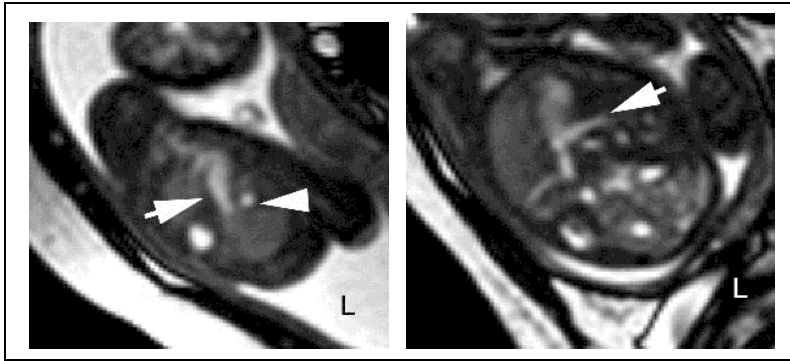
Left superior vena cava (SVC) diagnosed by axial T2-SSFP MRI at 26 weeks' gestation. (A) Three-vessel axial image documents absent right and persistent left SVC (arrowhead) as well as right sided aortic arch (arrow). (B) Axial MR image caudad to (A) shows left SVC (arrow) draining into a dilated right coronary sinus.
